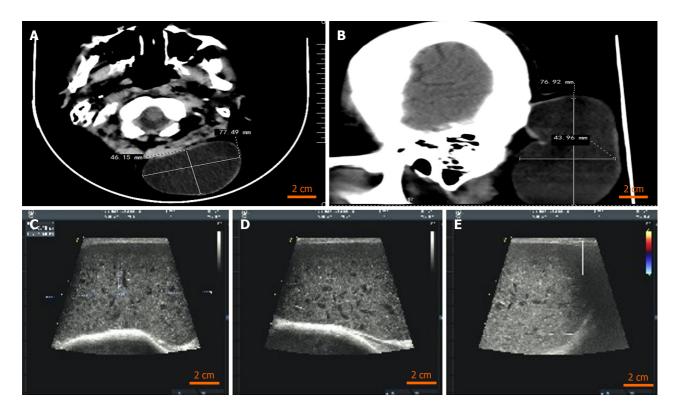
The computed tomography and ultrasonic image. A: The length and width of cyst of axial computed tomography (CT); B: The length and width of cyst of sagittal CT; C: A mass can be found at the subcutaneous distance of 2.3 mm from the body surface (ultrasonic image); D: The volume of the mass is 38 mm × 87 mm × 90 mm (ultrasonic image); E: The occipital mass is a solid mass with low echo, regular shape, clear boundary, complete envelope and less uniform internal echo (ultrasonic image).
